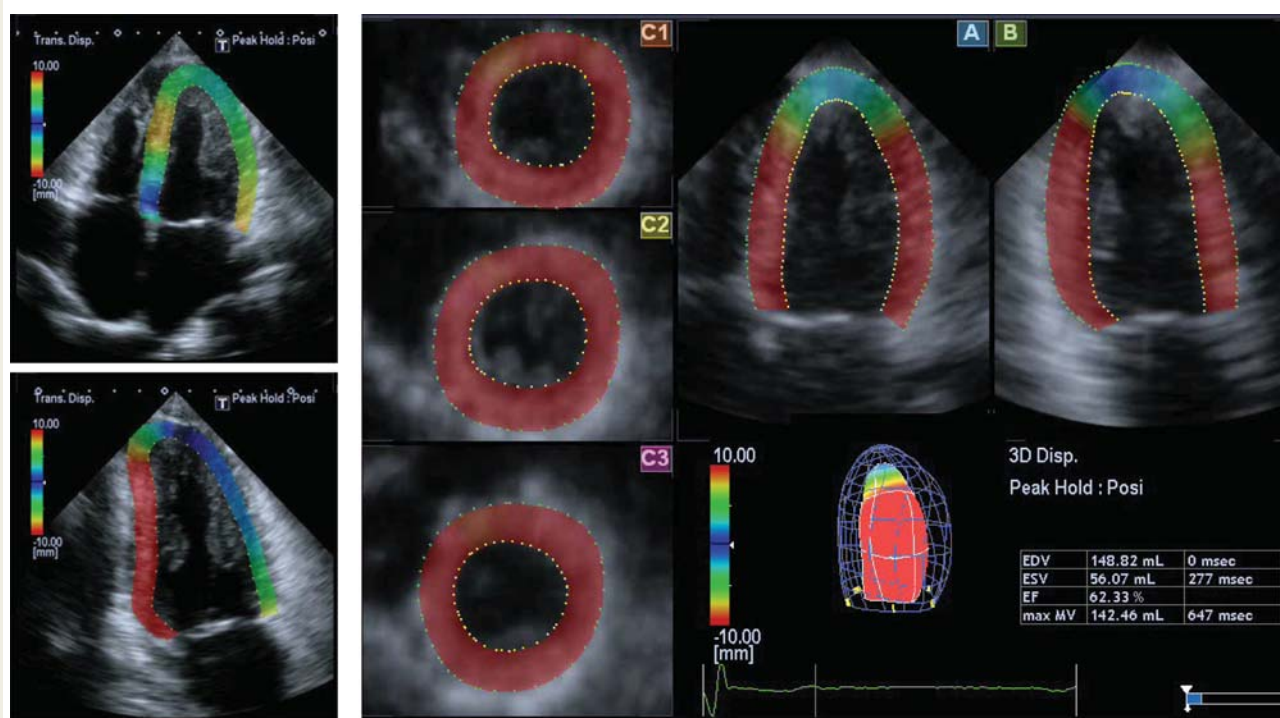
Example of images obtained at end-systole in a patient with normal LV function and concentric hypertrophy: 2D STE (left top, apical-four chamber [A4C] view; left bottom, apical two-chamber [A2C] view) and 3D STE extracted from the real-time 3D echocardiography pyramidal data set (right, [A] and [B]: A4C and A2C views; [C1–C3]: short-axis views from apex to base). The color patterns in both 2D views showed considerable variability in the measured regional displacement, as reflected by different colors, despite the normal LV function, reflecting out-of-plane motion of the speckles. In contrast, the 3D slices showed considerably more uniform color patterns, consistent with normal LV wall motion, in the short-axis views and also in the apical views, where one can also appreciate the gradual decrease in endocardial displacement toward the LV apex. Reproduced with permission from Nesser et al.²¹
